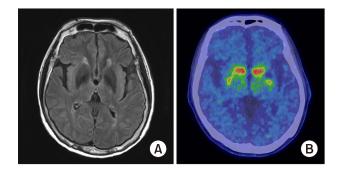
Brain image at the time of diagnosis. (A) No evidence of stroke or other structural abnormality in magnetic resonance image. (B) Decreased bilateral putaminal uptake in 18-flurodopa positron emission tomography scan.
